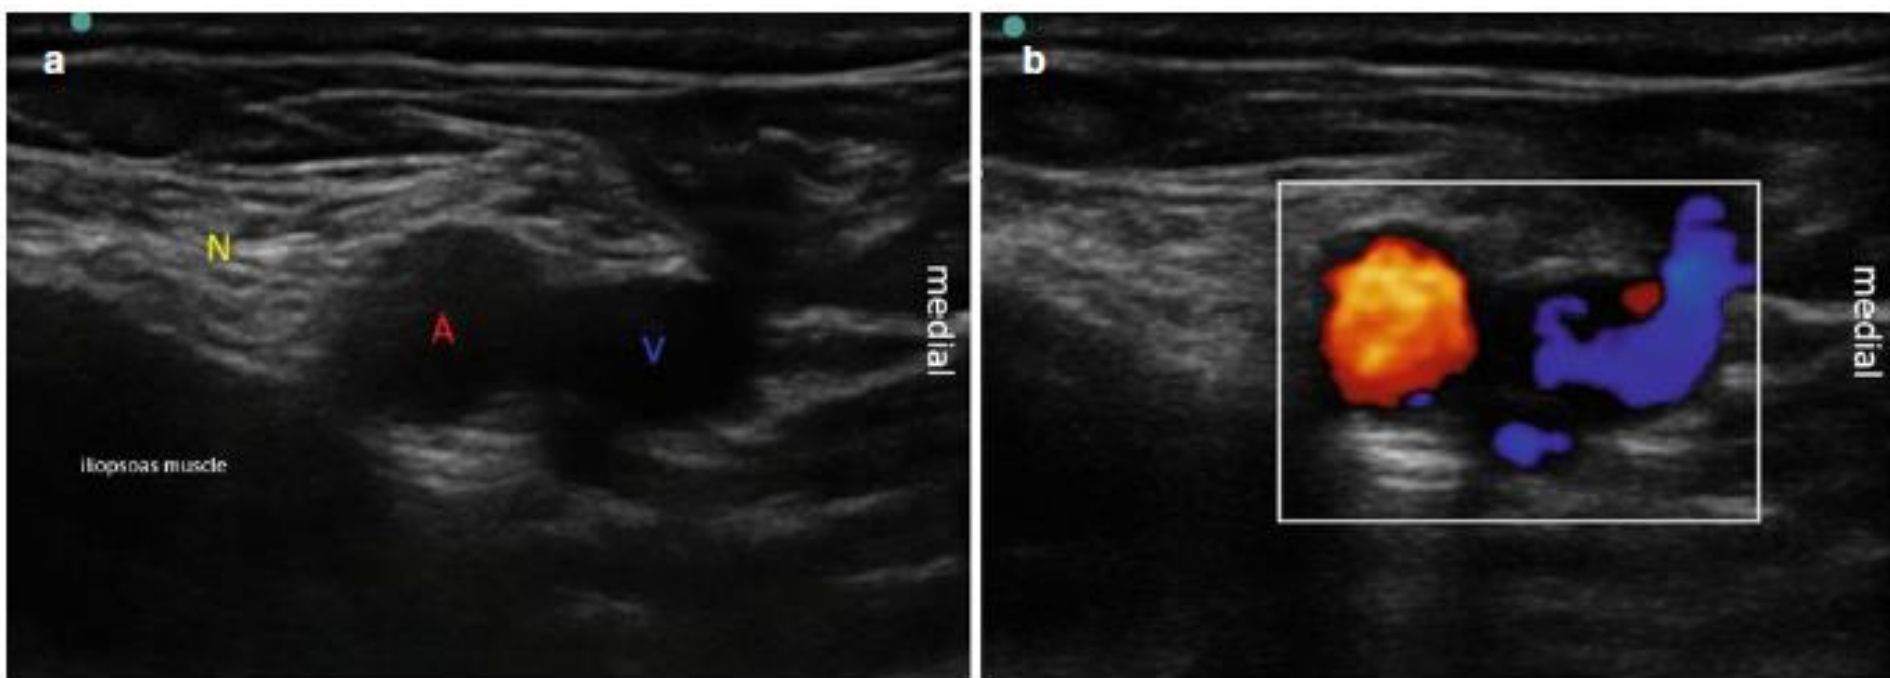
(a) Femoral nerve (*N*) in the inguinal crease, femoral artery (*A*), and femoral vein (*V*) as landmarks. (b) Color Doppler as a confirmation method (With permission from Jens Kessler)
